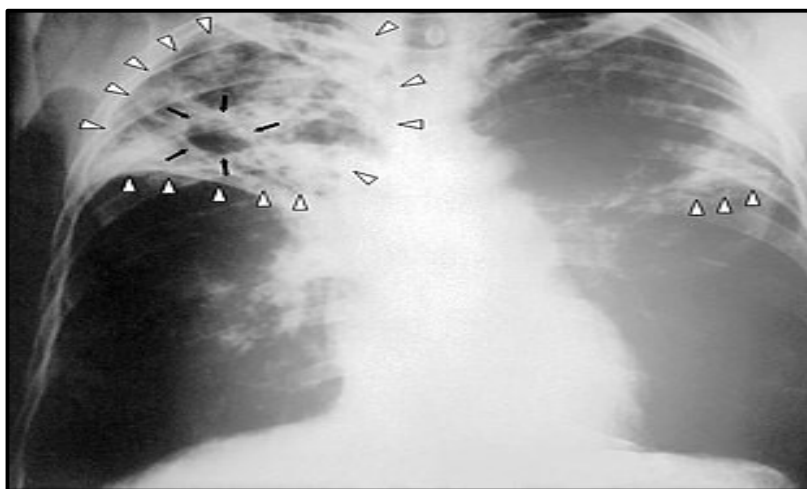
White arrowheads show infection in both lungs, and black arrows show the development of a cavity on a chest X-ray of an individual with advanced TB
